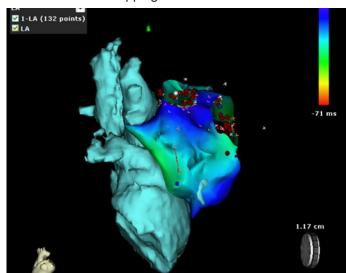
Image integration. Excellent fusion between computed tomography of the left atrium and electroanatomical mapping. Lateral view.
